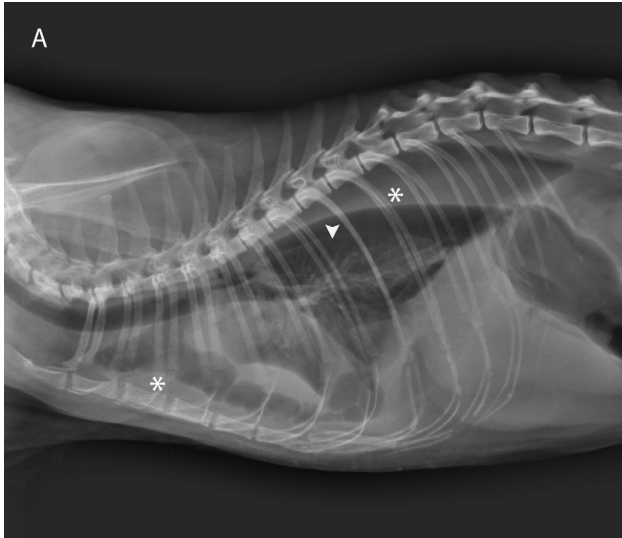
Same radiographic images as in Figure 1. Pleural fluid (asterisks) is evident bilaterally. Free gas is also present bilaterally in the pleural space (more severe on the left), and there is retraction of lung lobes from the thoracic wall (arrowheads). In the mid regions of the thorax bilaterally, there are multiple areas of homogeneous soft tissue opacity (arrows; B), consistent with atelectasis, trapped pleural fluid, or a multifocal alveolar pulmonary pattern.
